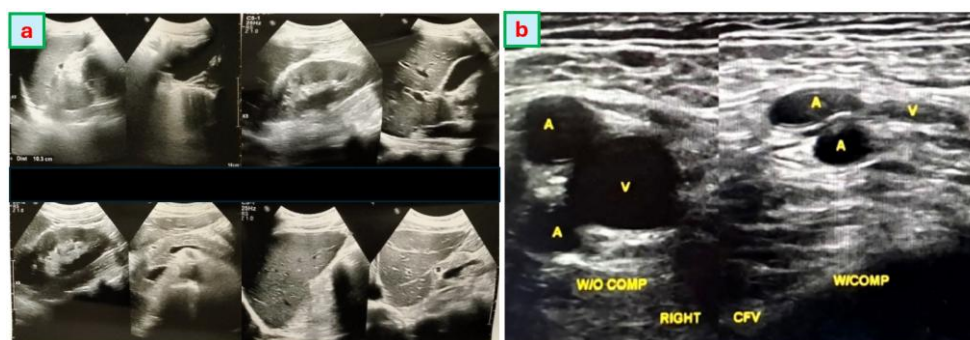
(a) Abdominal Ultrasound: No visible metastases in liver, spleen, kidneys, lymphadenopathy of paraaortic and suprarenal;
